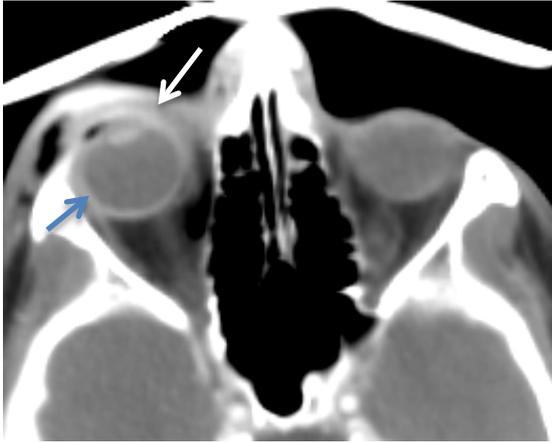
Unshaped vitreous body, right eye (23-year-old male with blurred vision). CT, axial section: Unshaped globe (white arrow) with an almond-shaped vitreous hemorrhage (blue arrow).
